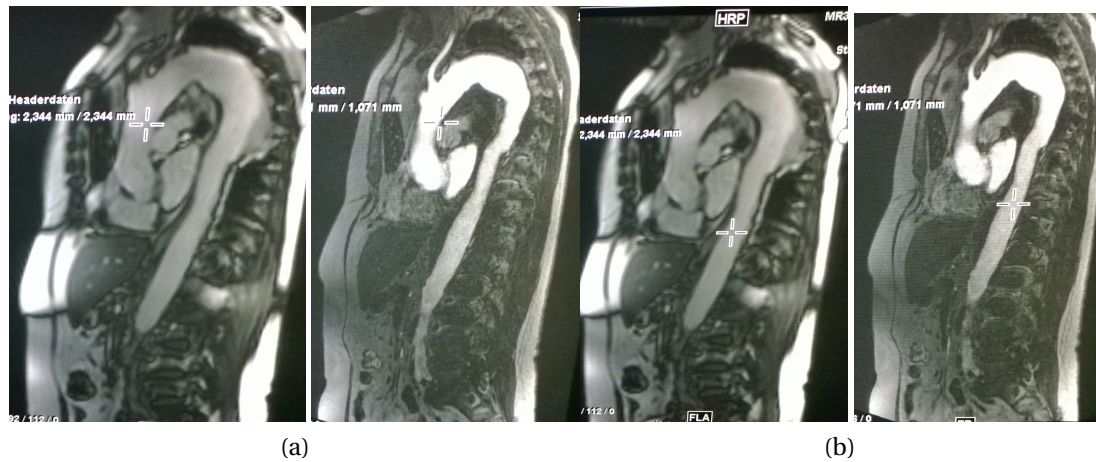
Available patient-specific PC-MRI measurements taken at the ascending (a) and descending aorta (b) on the planes indicated by the crosses in the images.
